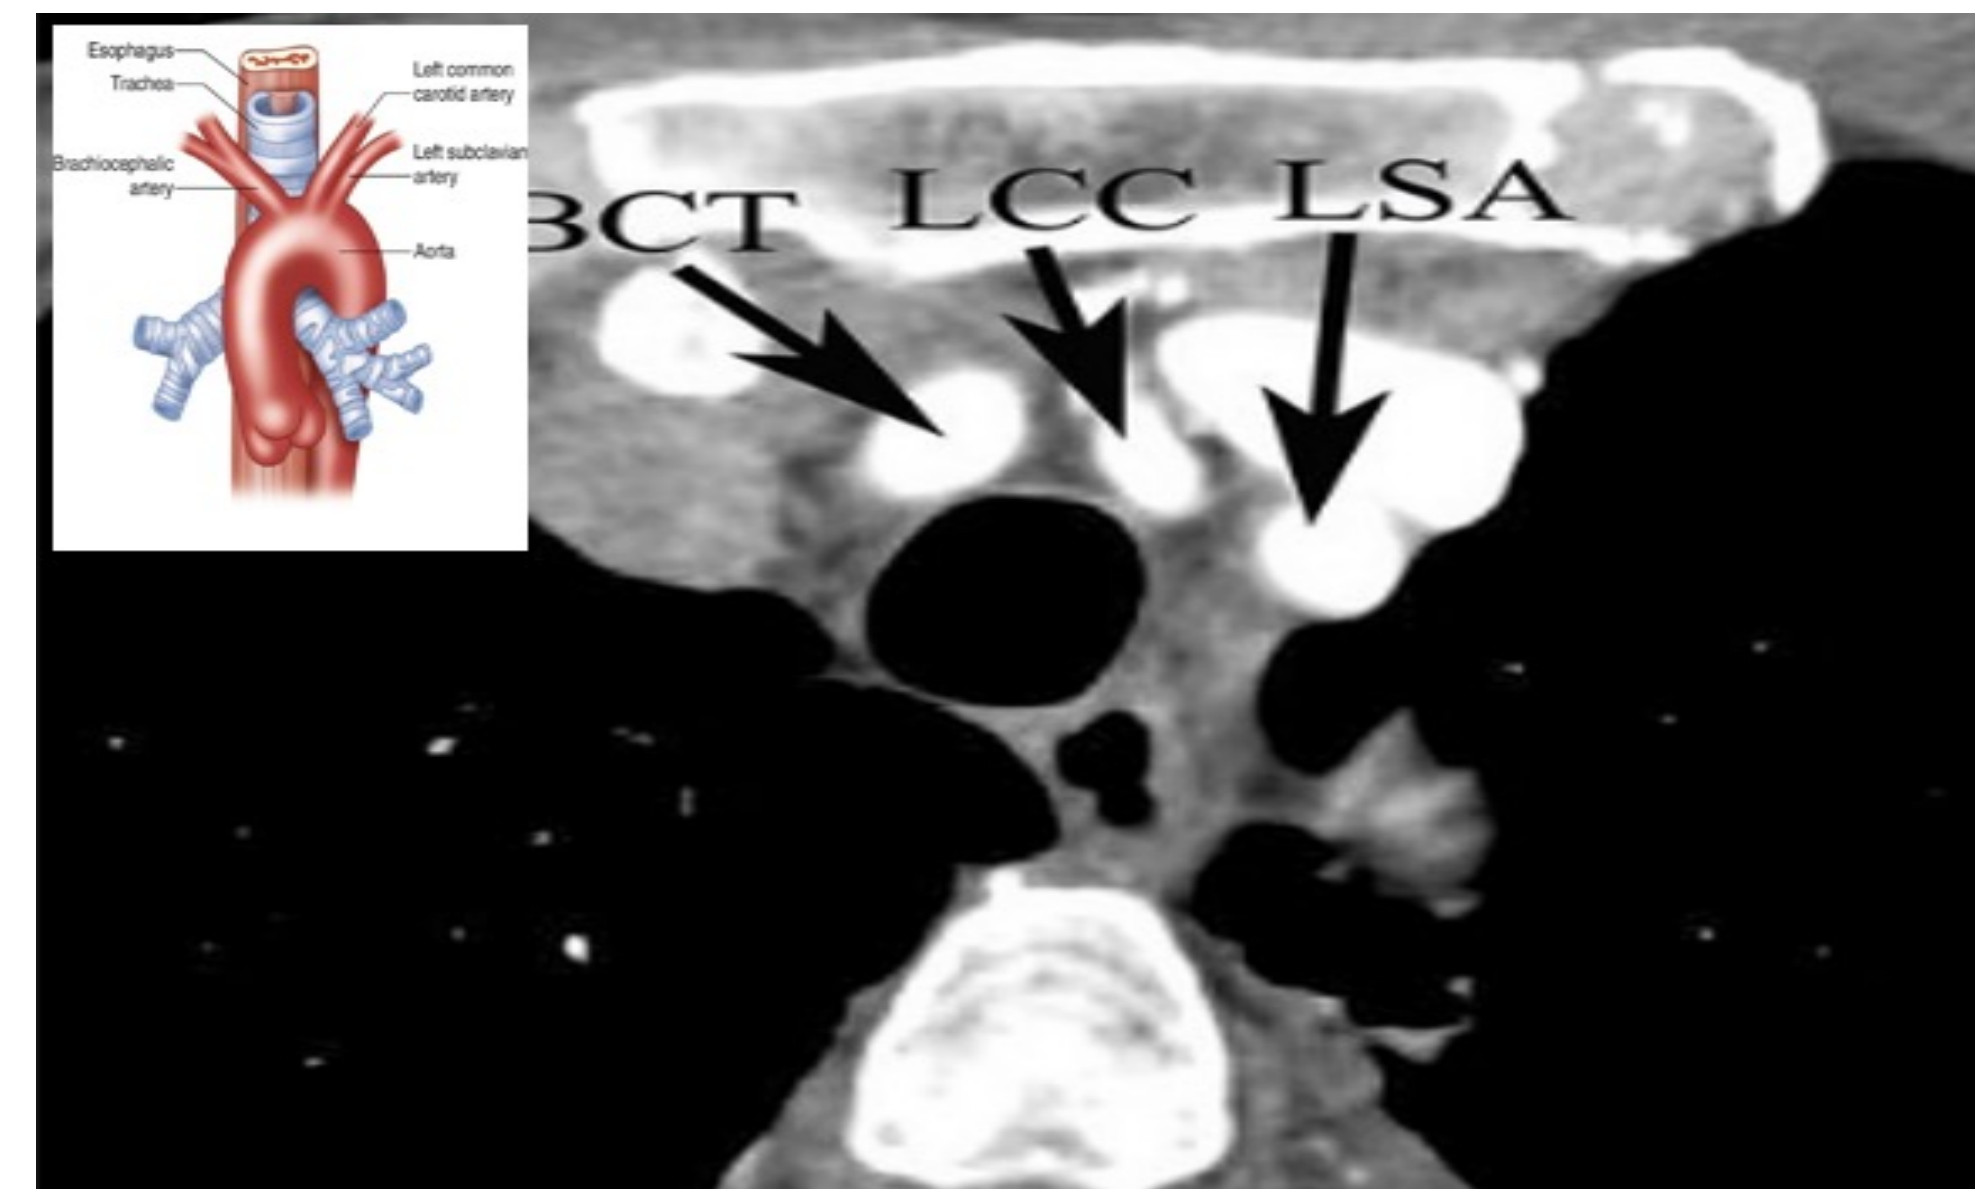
CT imaging of a patient with normal aortic arch anatomy. (1)
